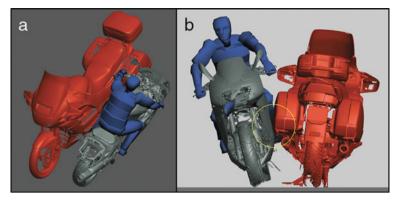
Biped reconstruction of a traffic accident based on surface scans of the motorcycles. The positions during impact have been reconstructed by combining damages on the vehicle with injury patterns documented by photogrammetry, surface scanning and CT
